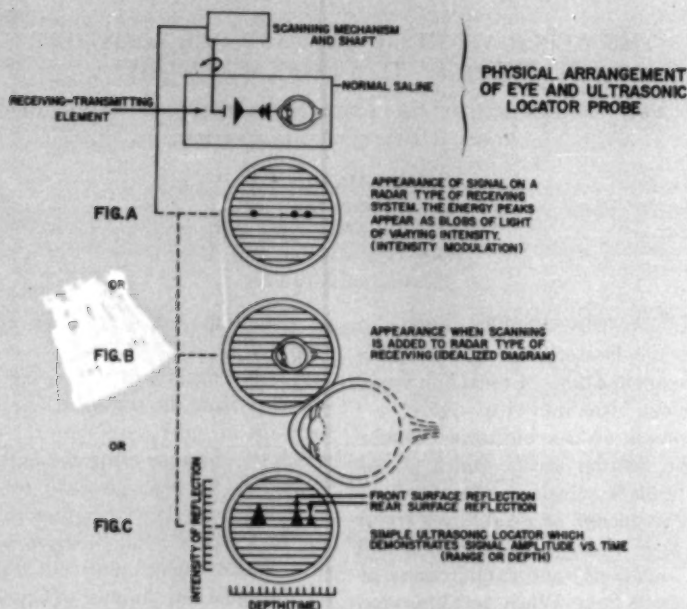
(Baum and Greenwood). Various methods of showing information obtained by ultrasonic localization.
